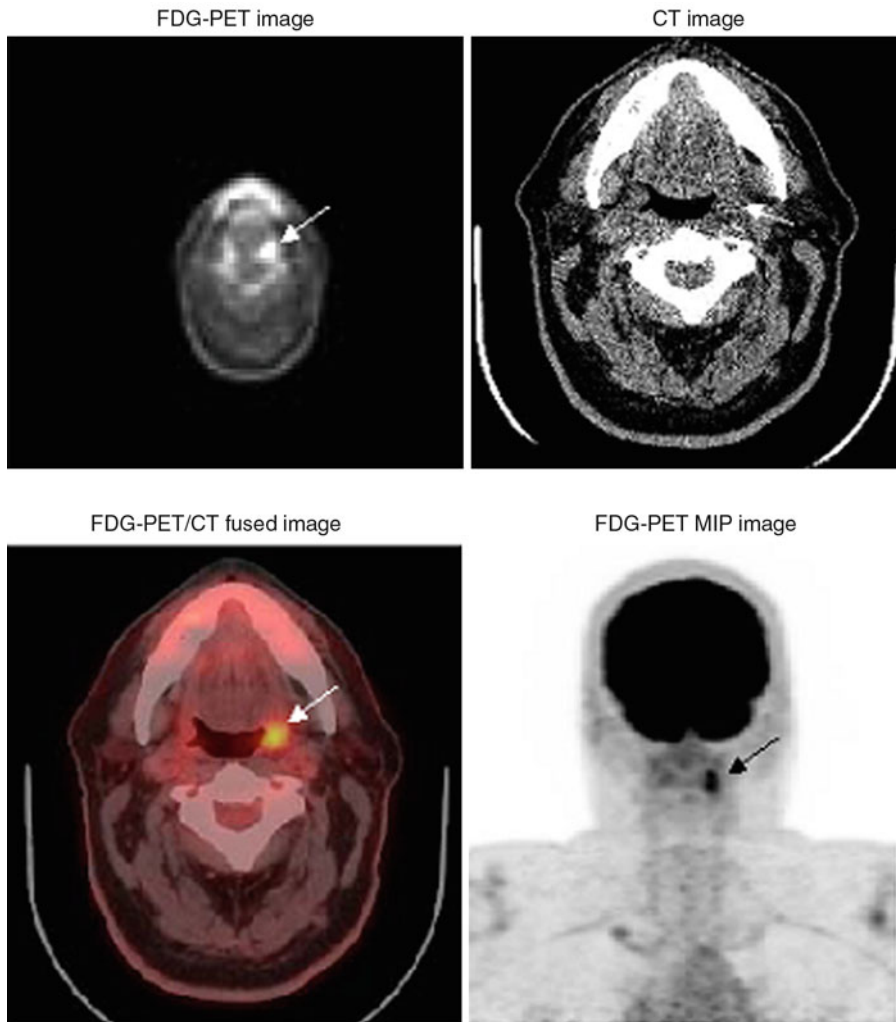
A 62-year-old male with recently diagnosed left tonsillar carcinoma. FDG-PET images show a focal abnormal uptake at the left tonsil represents the patient's known primary tumor with maximum SUV of 5.1 (*arrow*).
